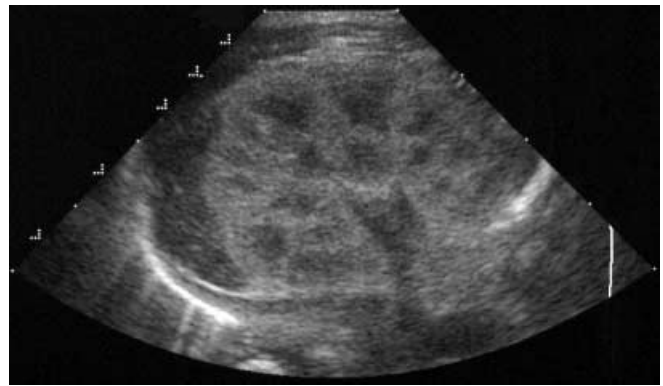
Normal renal ultrasound of a preterm infant born 33 weeks gestational age; kidney parenchyme is still hyperechoic in comparison to adjacent liver and spleen
